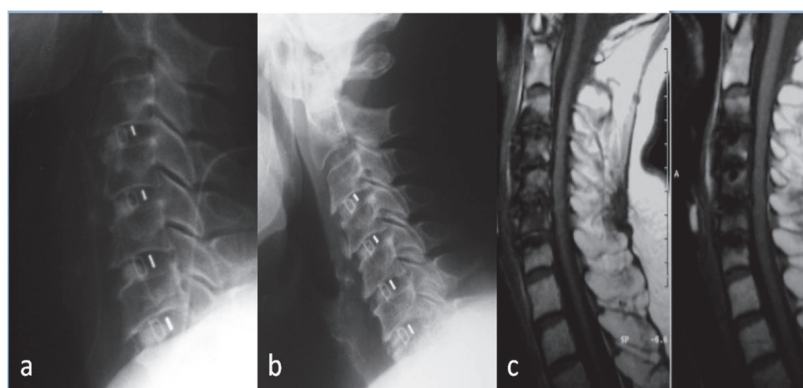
(a,b,c). Cervical radiographs obtained at the first follow-up examination 3 months postoperatively shows the restoration of the height of the disc space and preservation of the cervical spinal lordosis (a,b), and sagittal T1 weighted MR images obtained at the same time discern that the spinal cord had been successfully decompressed anteriorly (c).
